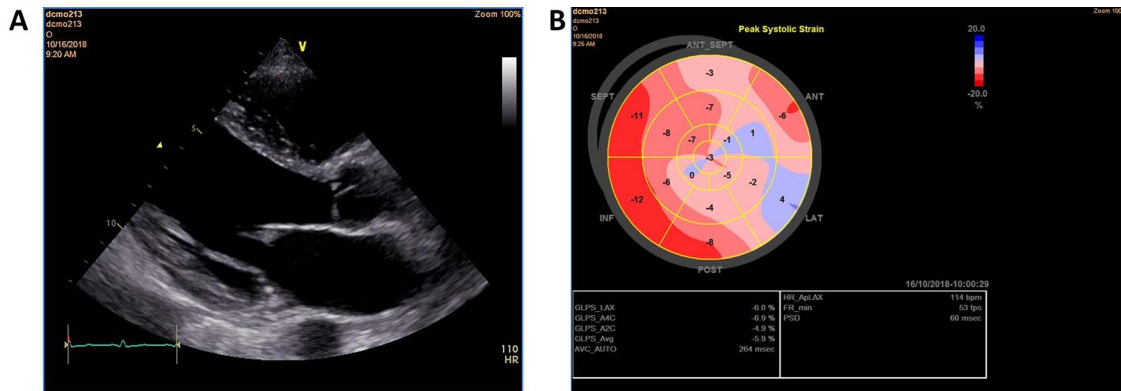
A: Echocardiography in a parasternal long axis view showing a dilated left ventricle and left atrium. B: Summary of the left ventricular global longitudinal strain pattern.
